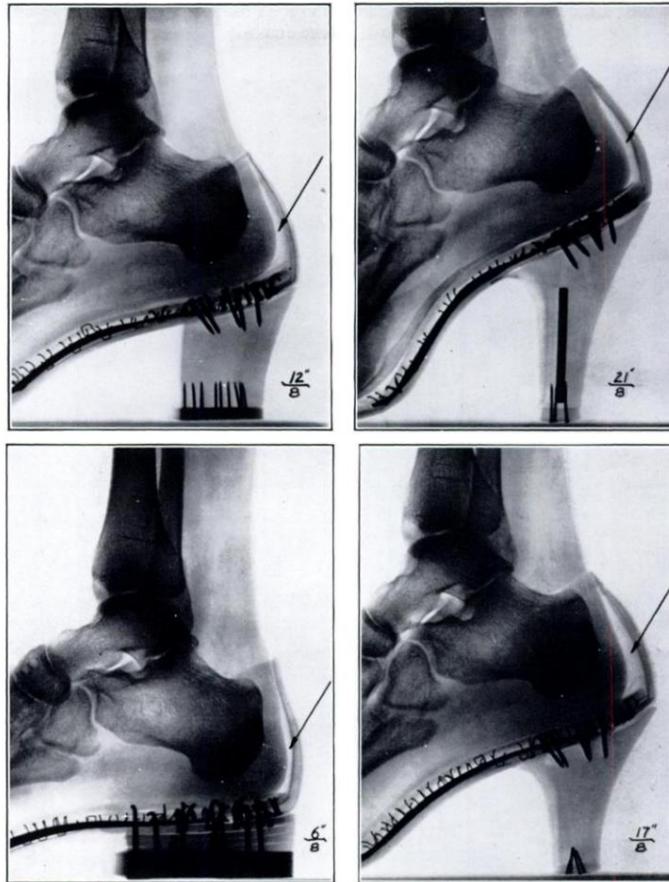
Example of the Sliding Forward of the Foot in the Shoe Accompanying Elevation of the Heel. Adapted from, “Preliminary findings from a roentgenographic study of the influence of heel height and empirical shank curvature on osteo-articular relationships of the normal female foot.” (B.P. Schwartz and A.L. Heath, 1959, *Journal of Bone and Joint Surgery*, 46-A: 1065–1076), Copyright 2016 by the Journal of Bone and Joint Surgery, Inc.
